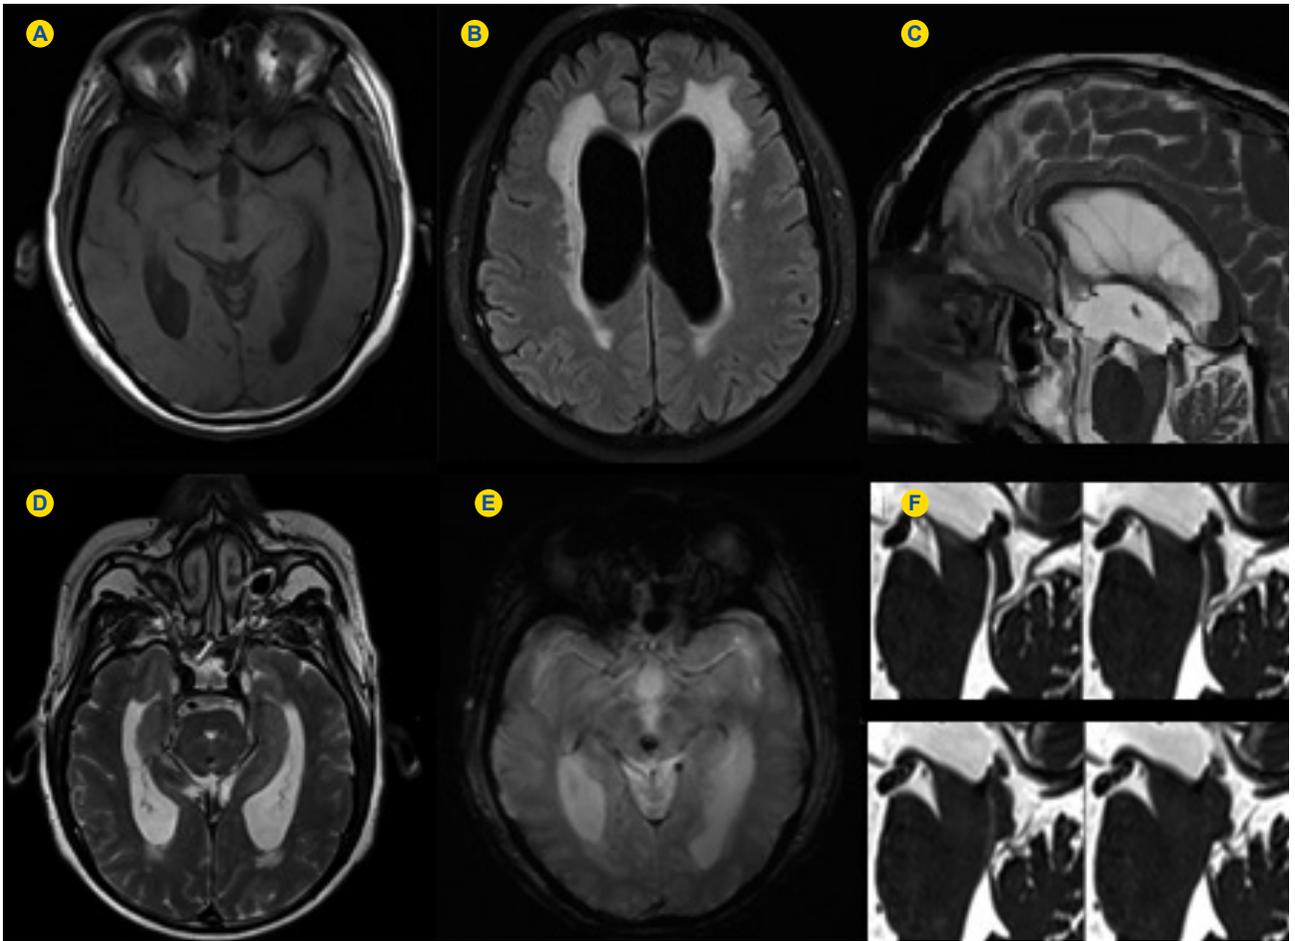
Pre-operative MRI: A,B,D,E, axial (A - T1 SE; B - T2 FLAIR; D - T2 TSE; E - T2 gradient echo); C, Sagittal T2 TSE; F, Sagittal 3D CISS reconstruction, MRI. Obstructive supratentorial hydrocephalus with interstitial edema, due to periaqueductal cavernous angioma with recent hemorrhage (T1 hyperintensity) to the aqueduct of Sylvius.
